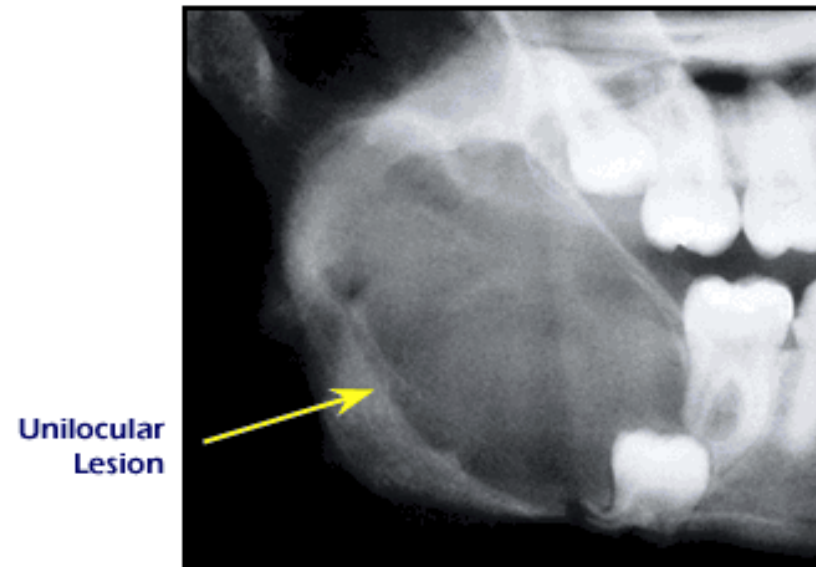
Large OKC involving an impacted third molar tooth, unilocular with scalloped borders, representing the typical radiographic appearance of OKC.
